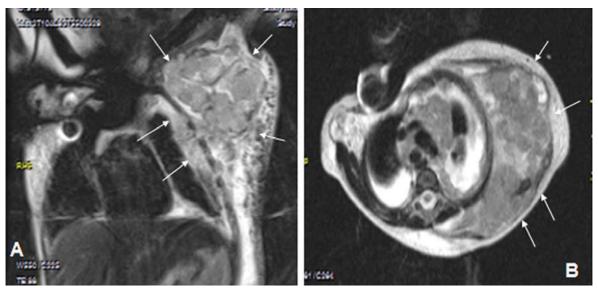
Coronal (A) and axial (B) T2-weighted images showing multiple conglomerated hypointense masses infiltrating the chest wall, pleura and mediastinum.
